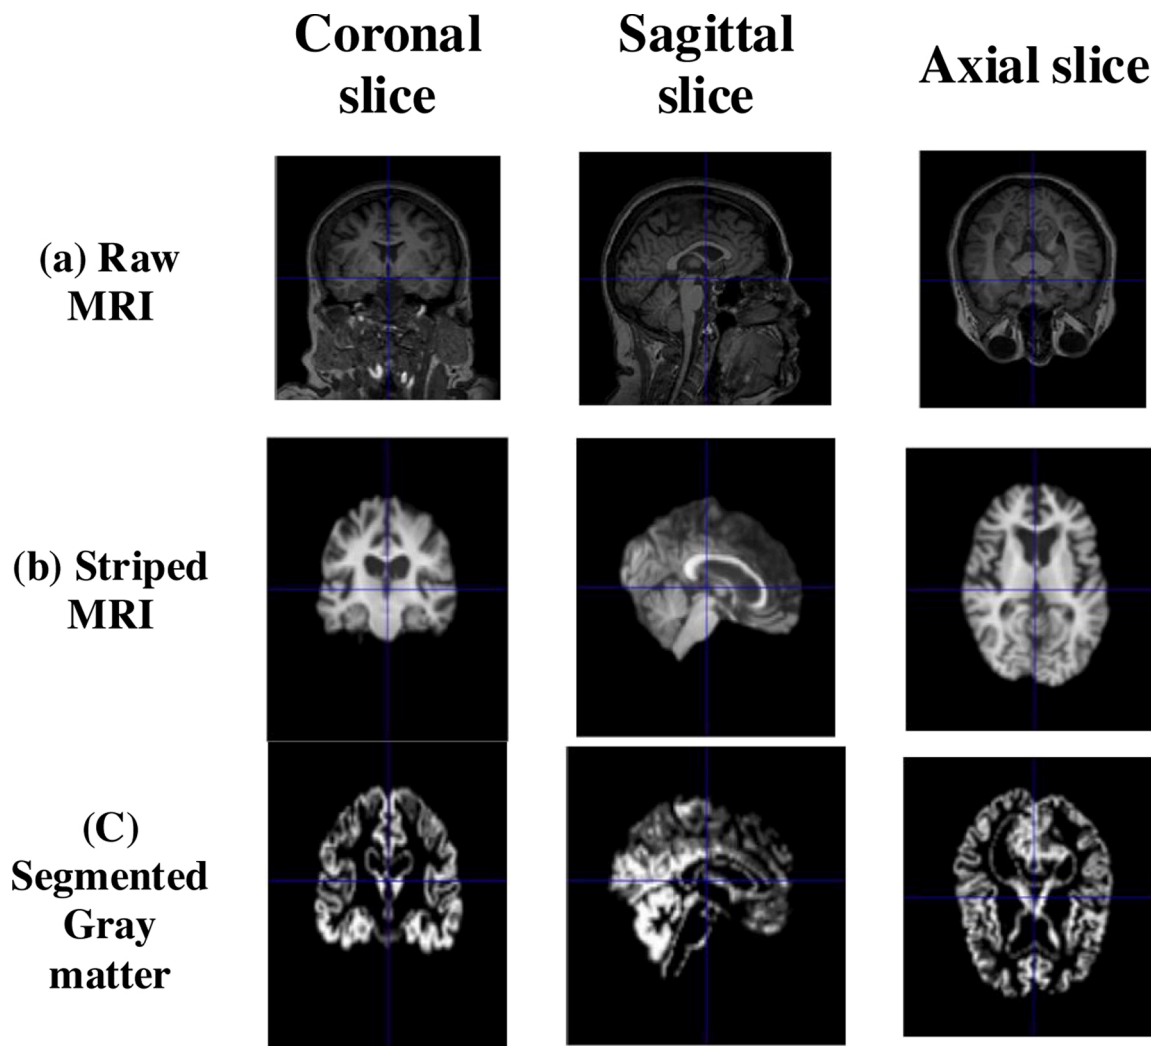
Figures (a) are raw MR images, figures (b) are striped MR images and figures (c) are segmented grey matter.
